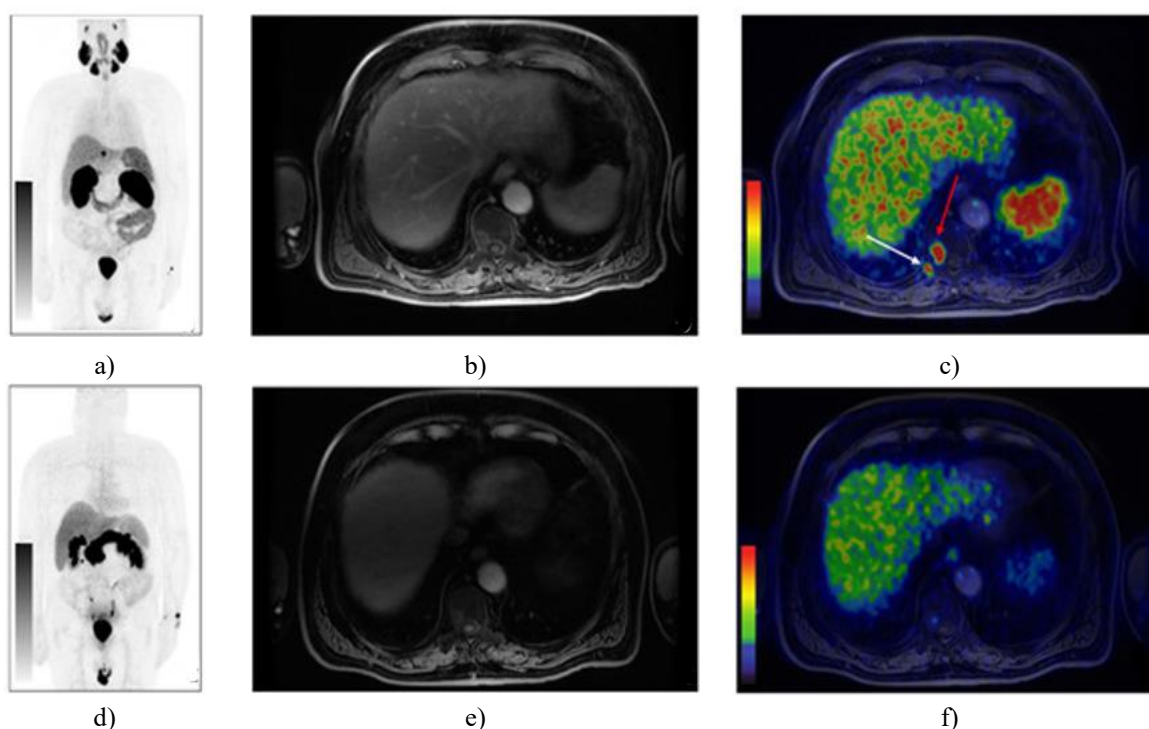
Example of Discordant PET/MRI Findings in Bone Metastases Detection
